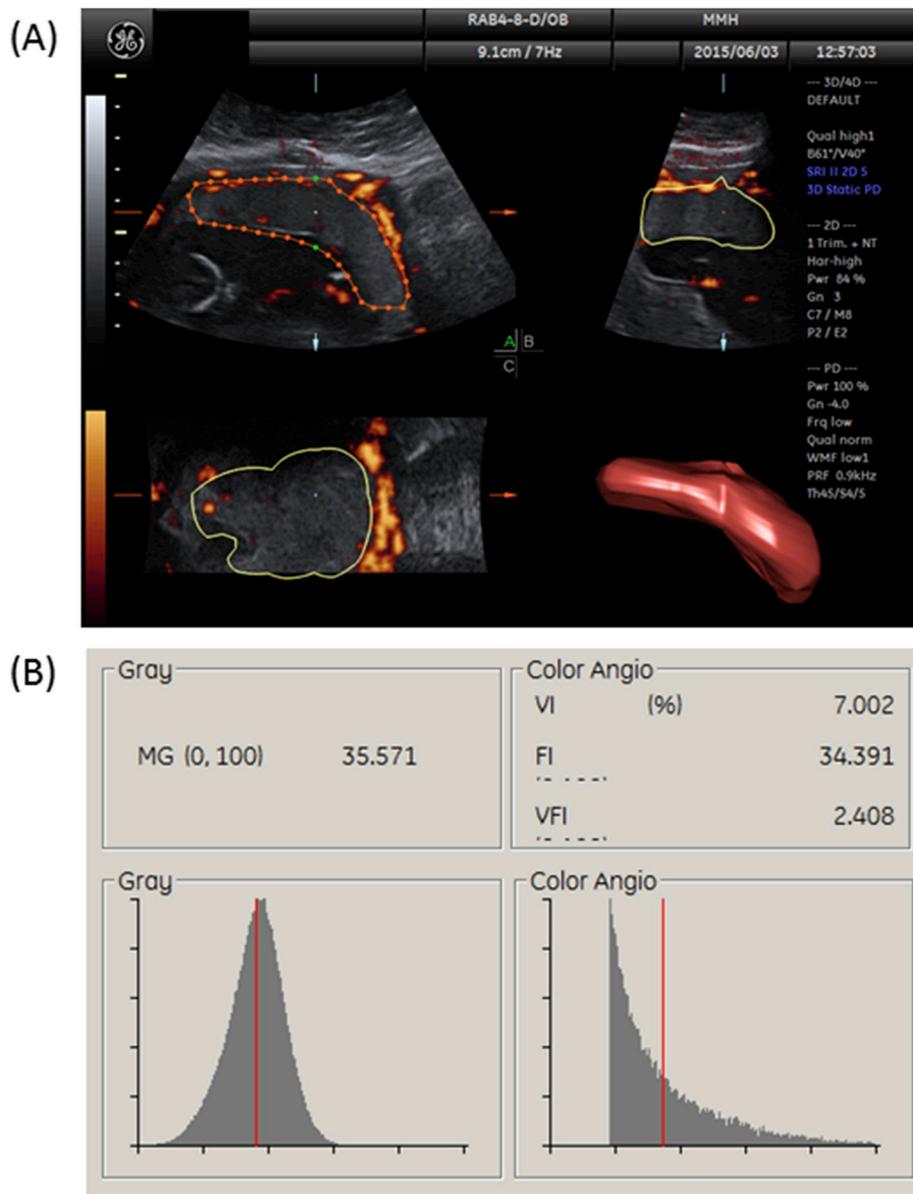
Assessment of placental vascular indices and placental volume using Virtual Organ Computer-aided Analysis (VOCAL™) imaging software. (A) Measurement of placental volume. (B) Placental vascular indices determined by three-dimensional power Doppler ultrasound.
